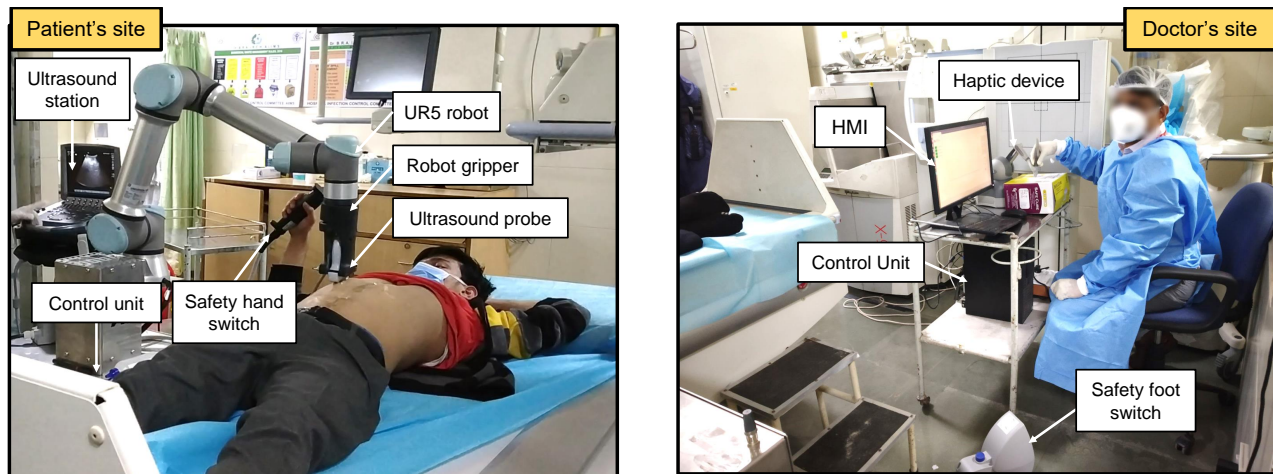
Telerobotic ultrasound (TR-US) system at AIIMS, Delhi, during the COVID-19 pandemic. The volunteer is undergoing abdominal US while the doctor, sitting at a safe distance (>6 feet) from the patient, manipulates the haptic device's stylus to control the precise movements of the US probe attached to the robot's end-effector.
